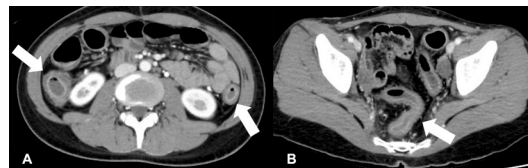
Contrast-enhanced CT scan of the abdomen on hospital admission. The wall of the (A) ascending colon, descending colon and (B) sigmoid colon is thickened. The lesions are shown with arrows.
